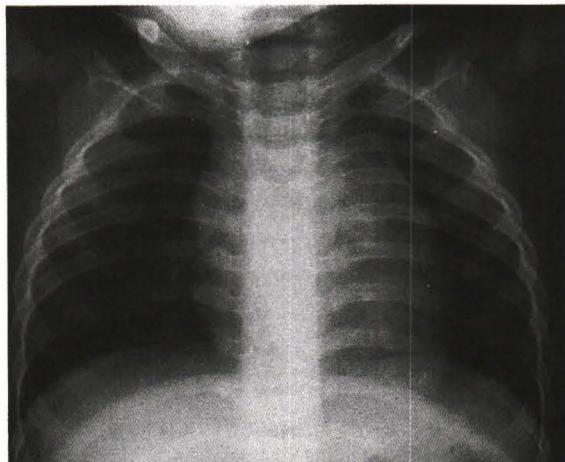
Chest X-ray shows marked improvement of multiple lung cysts at 7 months old.
